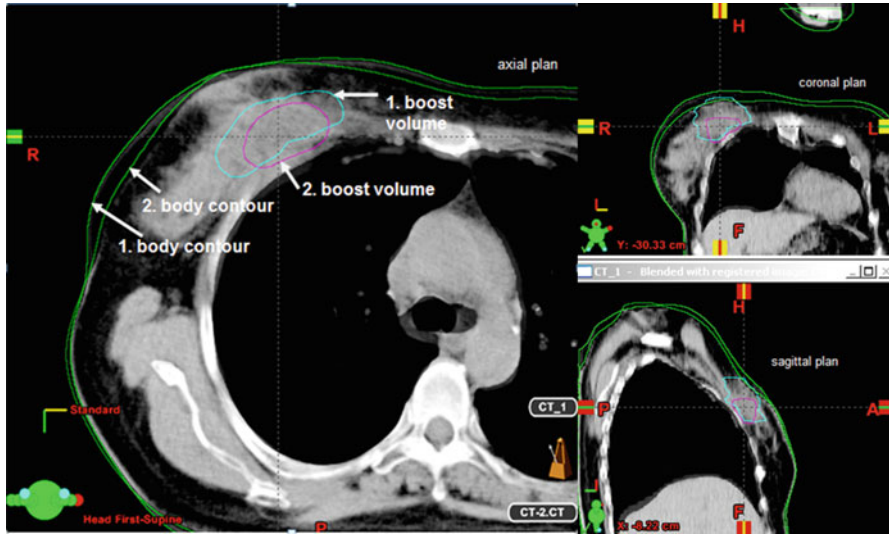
The changes of the body contour and boost (seroma) volume between two CT images in the same patient with 28-day intervals (*left*), overlay of two boost volume on sagittal (*right upper*) and coronal (*right lower*) slices. The volume of seroma (cyan line) was 67 cm^3 on the first planning CT image and 16 cm^3 on the second CT image (magenta line). The smaller tumor bed volume allows for less normal breast tissue to be included within the radiation field
